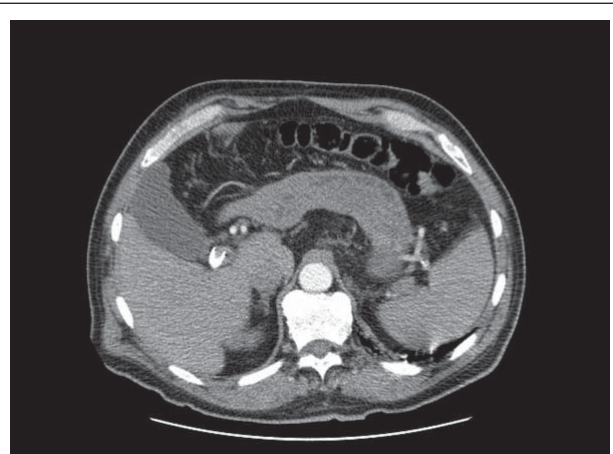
Contrast-enhanced CT scan of the abdomen performed 2 weeks post TIPS. The previously seen mass is no longer visualized.
